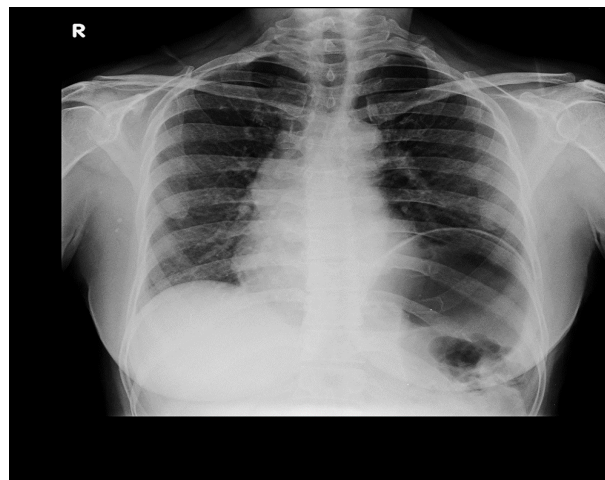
Chest x-ray erect (PA view) showing herniation of the gastric fundus into the left hemithorax in paracardiac region.
